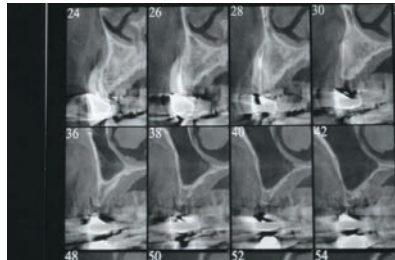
CT scans show the vertical and horizontal ridge atrophy.
